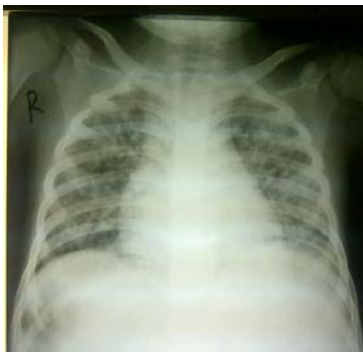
Patient's chest x-ray showed diffuse bilateral and patchy infiltrate
